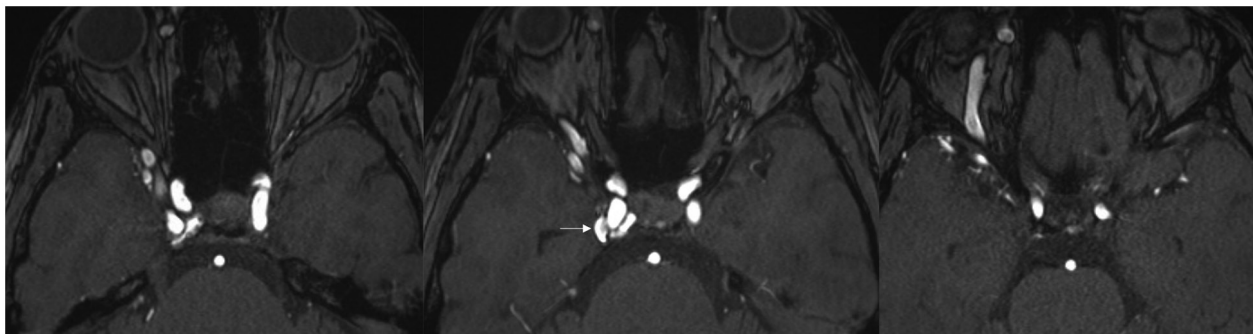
MRI on admission. Time-of-flight-MRA on admission shows enlargement of the SOV and significant flow signal at the right
